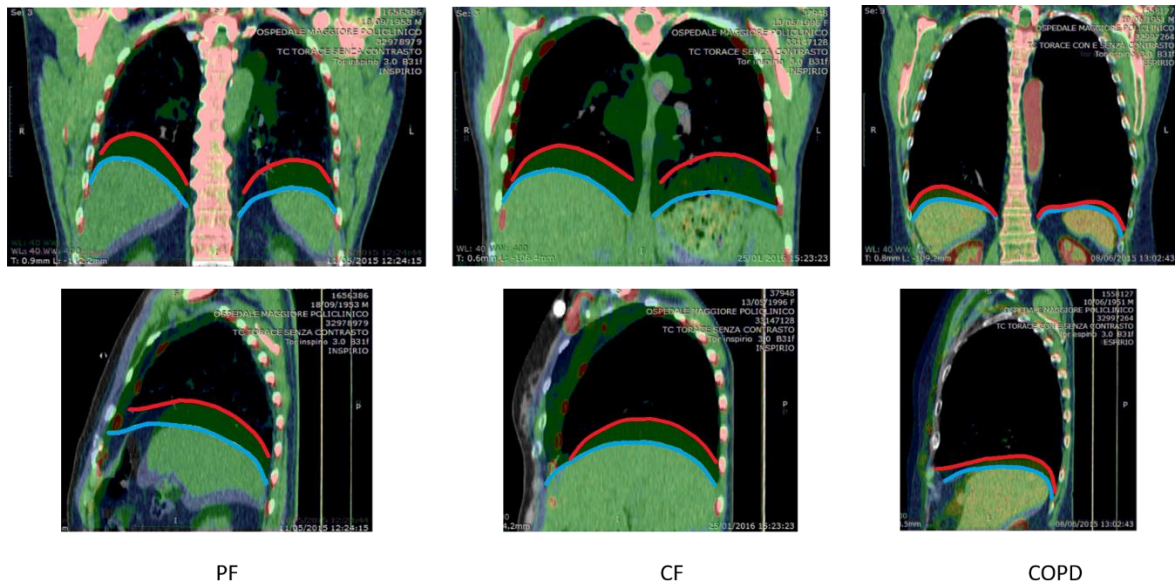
from the left: PF, CF and COPD CT images acquired at TLC and RV, in the coronal plane (on the top) and sagittal plane (at the bottom)
